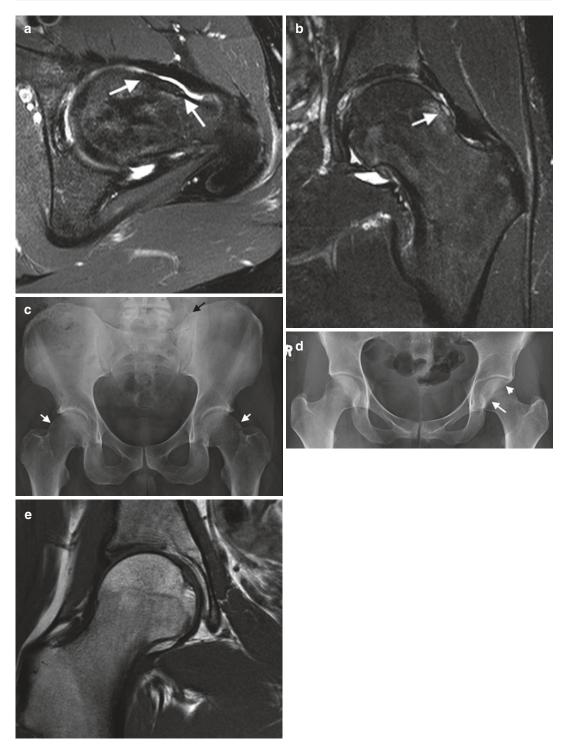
(a) Axial oblique and (b) Coronal T2FS demonstrating femoral head-neck dysplasia (*arrows*) with associated mild bone marrow oedema; (c) AP pelvic radiograph demonstrating femoral head–neck dysplasia (*arrows*), incidental left transitional vertebra; (d) acetabular retroversion and (e) normal Cor T1 MRI right hip for reference
